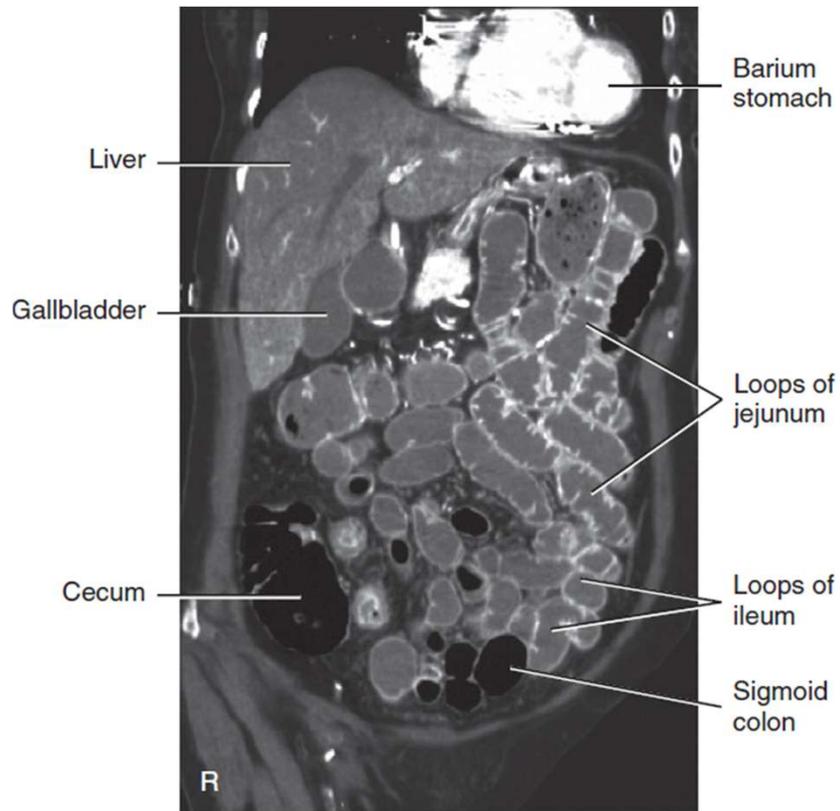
CT enteroclysis.
